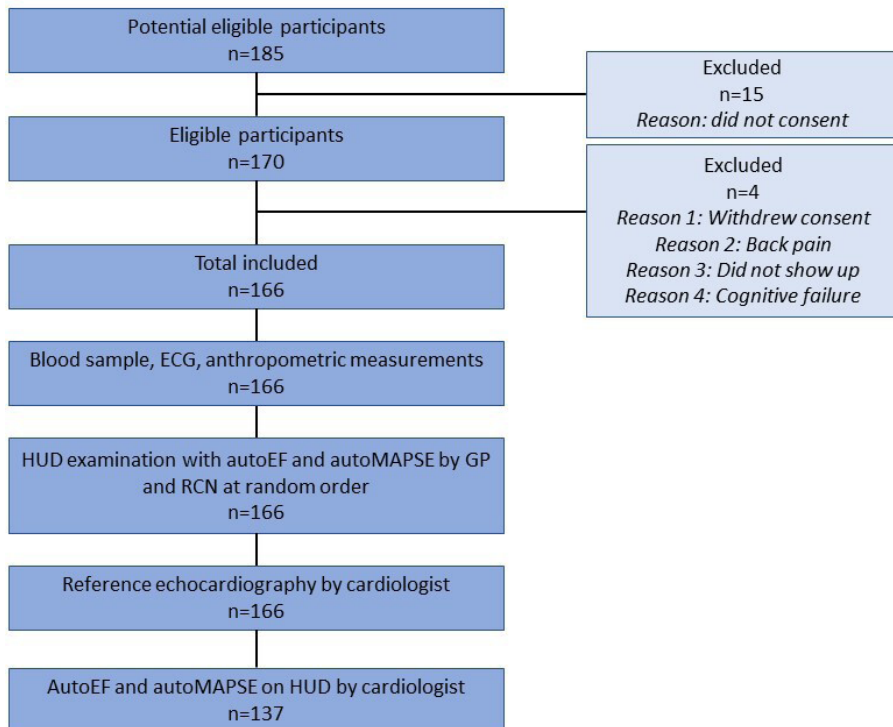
Study flow. AutoEF, automatic measurement of left ventricular ejection fraction; autoMAPSE, automatic measurement of mitral annular plane systolic excursion; GP, general practitioner; HUD, hand-held ultrasound device; RCN, registered cardiac nurse.
